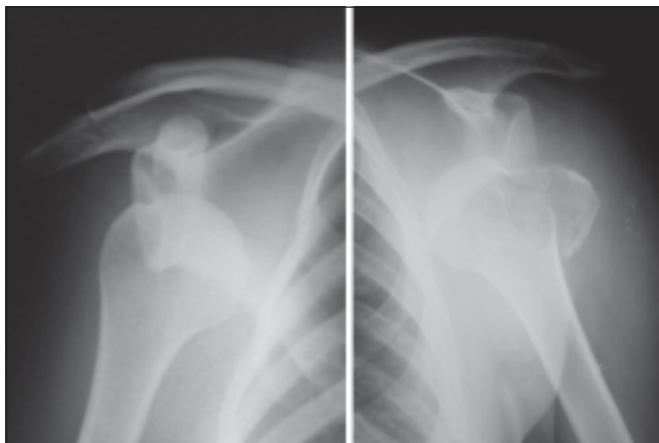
Radiograph showing anterior dislocation of shoulder displaced without and with greater tuberosity fractures
